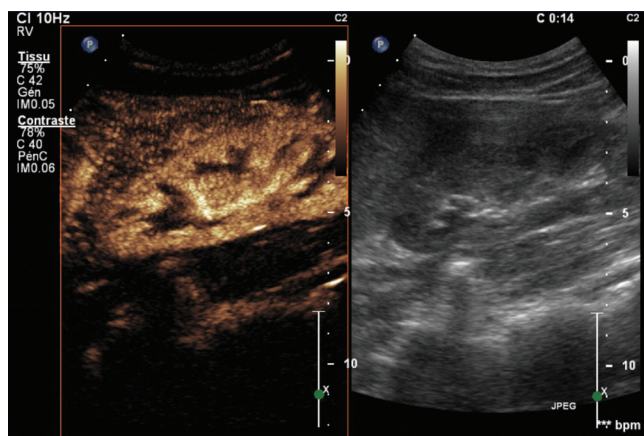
See also color plates. Normal contrast-enhanced ultrasound (CEUS) perfusion image. Longitudinal view of the right kidney in a 39-year-old woman, investigated for suspicious renal mass at the upper pole. No mass is visible, neither on fundamental image (*right*) nor on CEUS (*left*). The CEUS image shows a homogeneous arterial perfusion of the kidney. In the arterial phase, because of predominant portal phase, the liver remains hypoperfused in comparison with the kidney.
